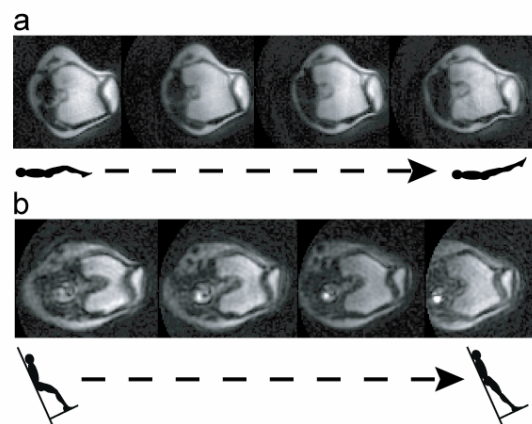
Real-time MR images of patellofemoral joint during (a) supine, low-load knee extension and (b) upright, weight-bearing knee extension.
